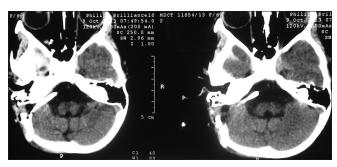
Postoperative computed tomography scan demonstrating the placement of Ommaya reservoir with the tip of the reservoir tube placed inside the cyst cavity
